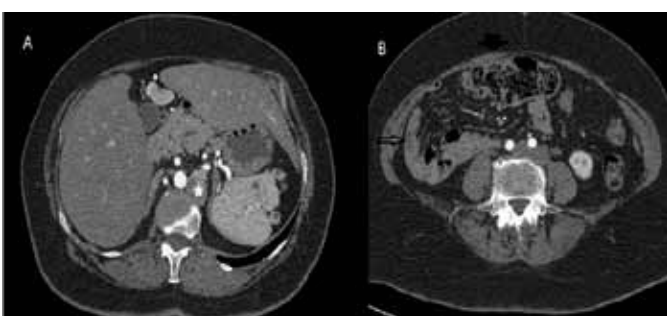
Contrast-enhanced computed tomography axial images of the patient. (A) There is a midline liver, a left-sided stomach and lobulated spleen with multiple accessory spleens (black stars), a midline gallbladder (thin white arrow) and an anteriorly positioned portal vein (small thick white arrow). The pancreas is truncated. Inferior vena cava is located on the left side of the abdominal aorta (white star), (B) The small bowel is right-sided (black empty arrow) and a colon left-sided (black thick arrow).
